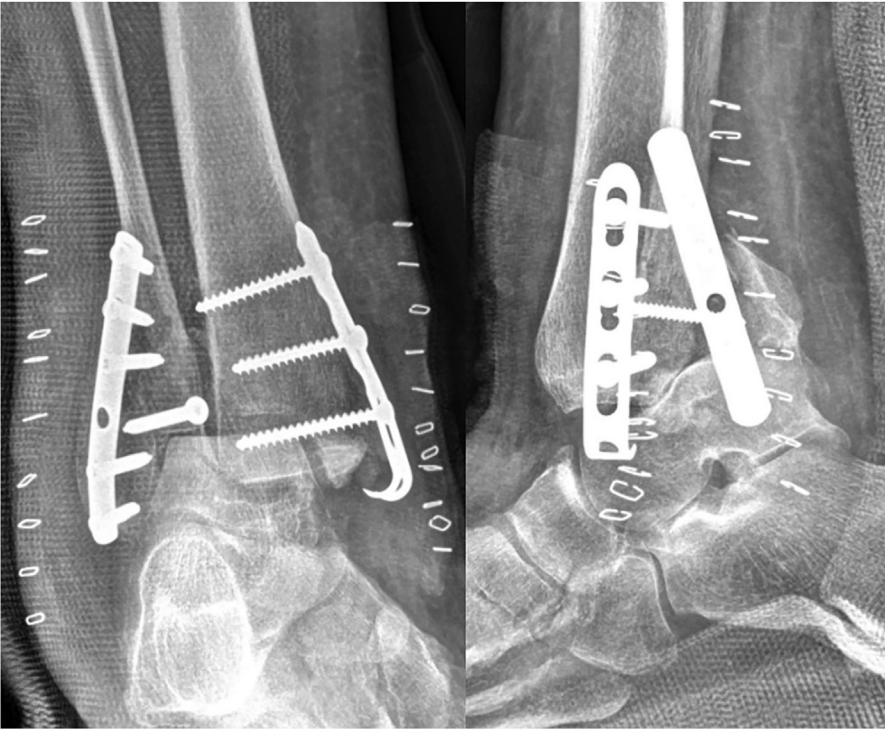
Postoperative radiographs of same patient depict early failure within 2 weeks of surgery at another medical center. Note the absence of syndesmosis screws, which may have prevented re-dislocation. The patient developed a large anterior distal tibial wound and eventually required below-knee amputation.
